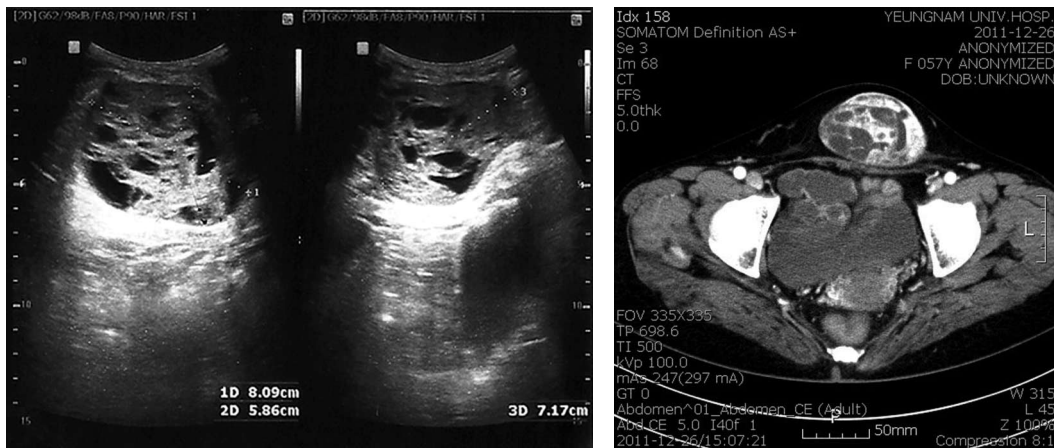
(A) Ultrasonography shows a lobular and solid tumor in the subcutaneous region. (B) CT reveals a nine-cm heterogeneous and strongly enhanced mass.
